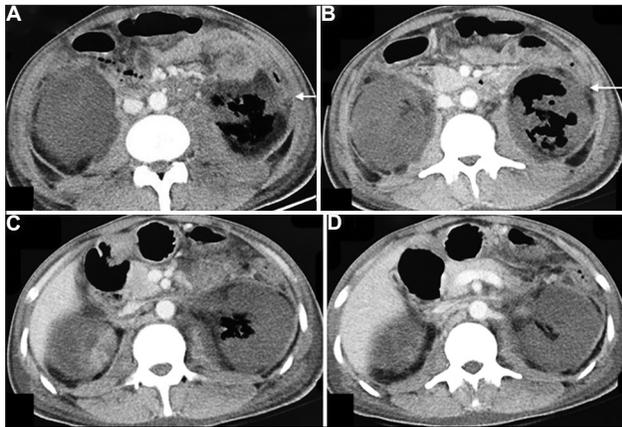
(A-D) Contrast-enhanced computed tomography abdomen axial images showing bilateral non-enhancing globular enlarged kidneys with perinephric inflammation and left emphysematous pyelonephritis replacing the left kidney (arrow).
